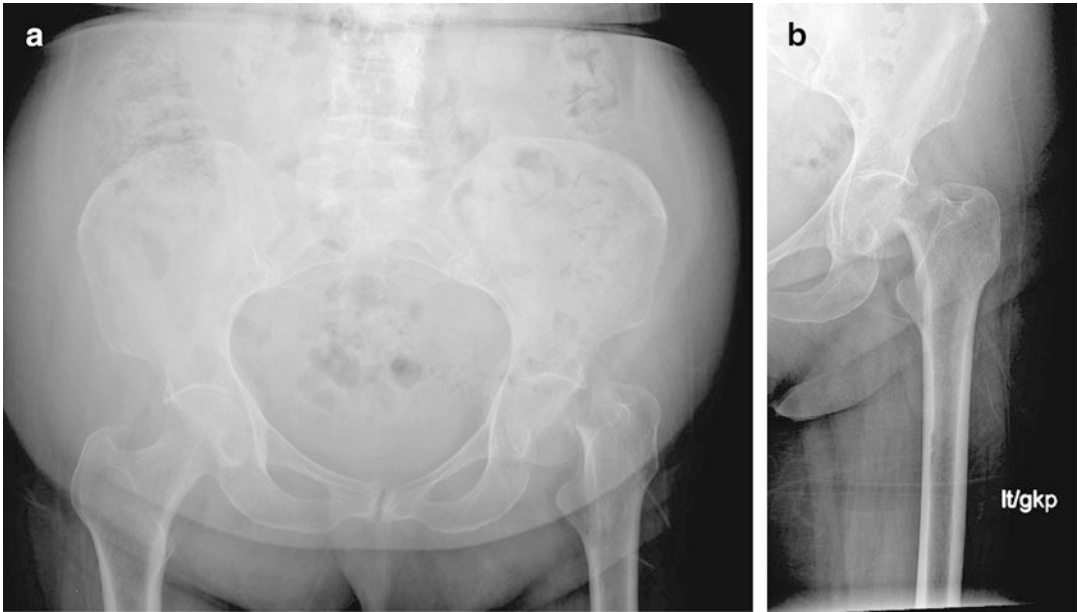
(a) Pelvic radiograph (b) Left hip radiograph
